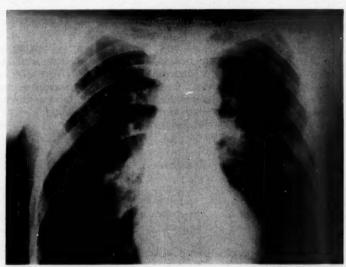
Appearance of the chest of case 1 by x-ray examination in January, 1959. Note increase in cardiac size and clearing of the pulmonary infiltration which occurred during treatment with sulfonamides and substitution corticoid therapy.
